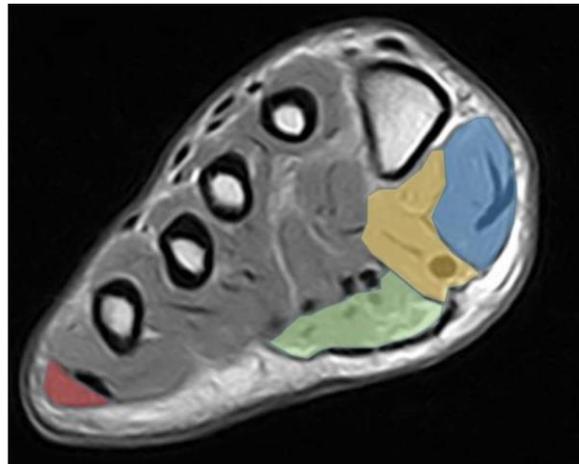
Example of a MRI slice and the four muscles of interest circumscribed. Abductor digiti minimi (in red), flexor digitorum brevis (in green), flexor hallucis brevis (in yellow) and abductor hallucis (in blue).
